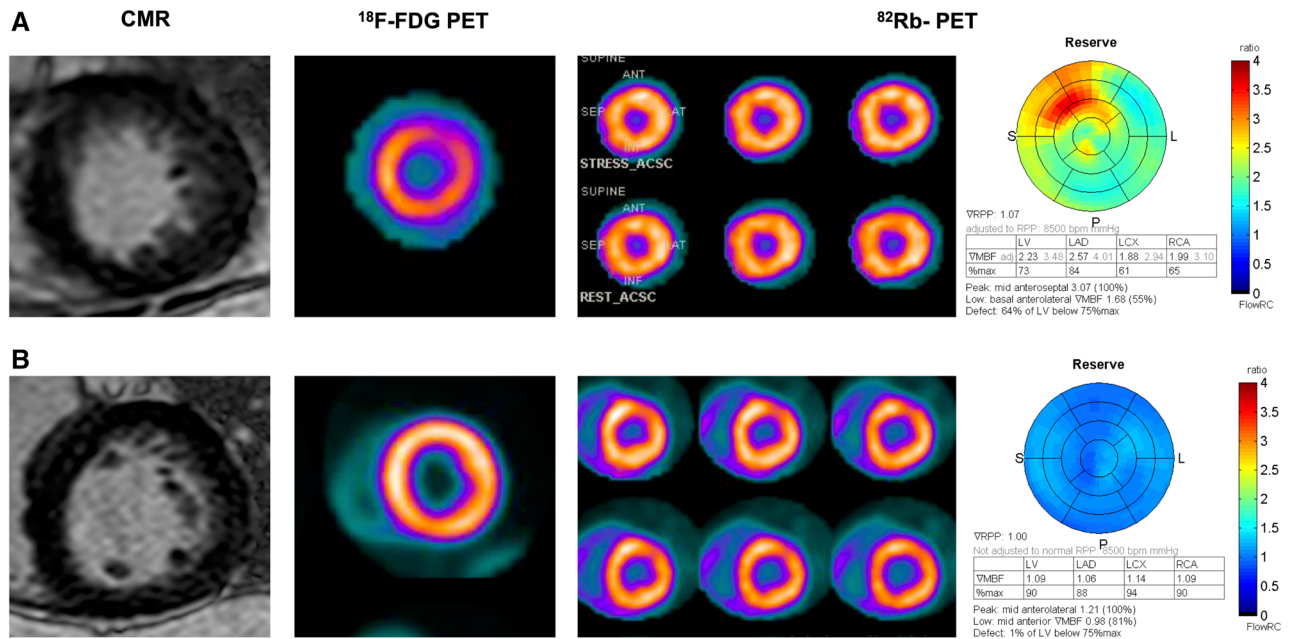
Cardiac magnetic resonance (CMR), ^{18}F -FDG PET, and stress-rest ^{82}Rb PET in two patients with AFD. (A) 48-year-old woman and (B) 53-year-old man. Both patients had normal LV mass, thickening, and size on cine images without evidence of late-gadolinium enhancement at CMR. Both patients also had homogeneous ^{18}F -FDG myocardial uptake and normal perfusion by stress-rest ^{82}Rb imaging. On the contrary, myocardial perfusion reserve was normal in the first patient and severely reduced in the second.
